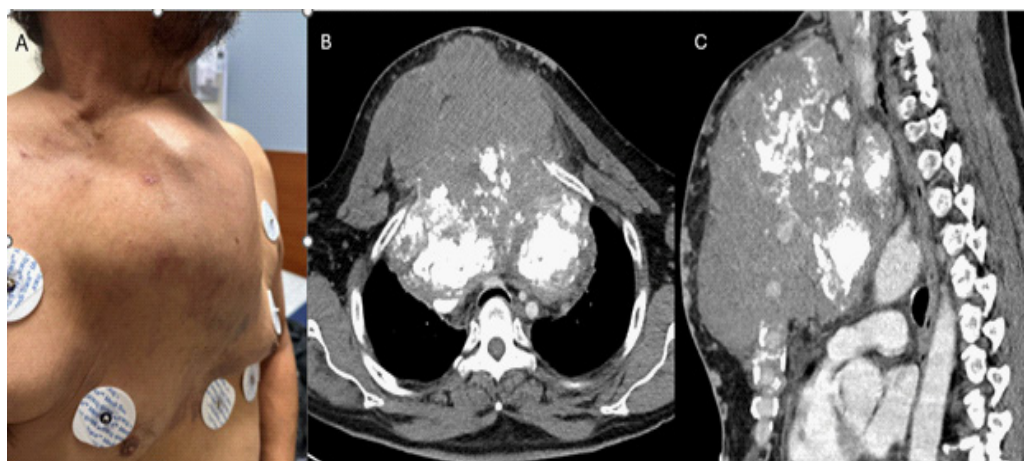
(A) Clinical image showing a large anterior chest wall mass with overlying dilated vein. (B) Axial CT showing a 15.2 × 18.2 × 16.6 cm lobulated, calcified mass invading the sternum, extending into the chest wall, and compressing the trachea.
